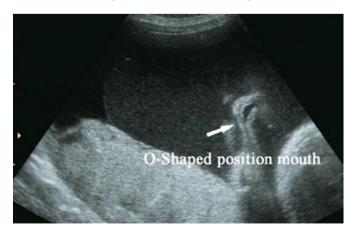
Ultrasound showing an open mouth in the shape of an "O". ¹³
